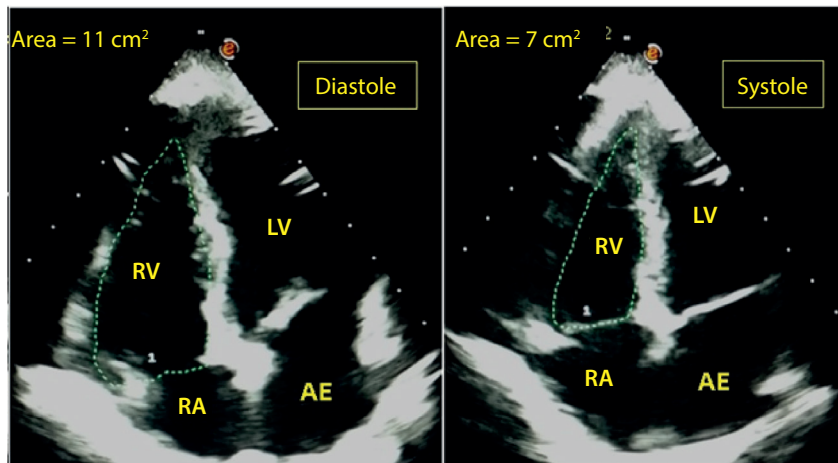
Apical 4-chamber view showing the fractional variation of the RV area. FAC: $(11-7)/11 = 36\%$.
